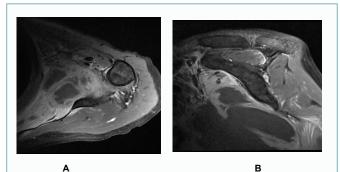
Contrast-enhanced magnetic resonance (MR) imaging of left shoulder. Axial and sagittal fat-suppressed, T2-weighted images showing large intramuscular complicated fluid collection of 10.0 × 5.2 × 11 cm in size at the level of the subscapularis muscle.
